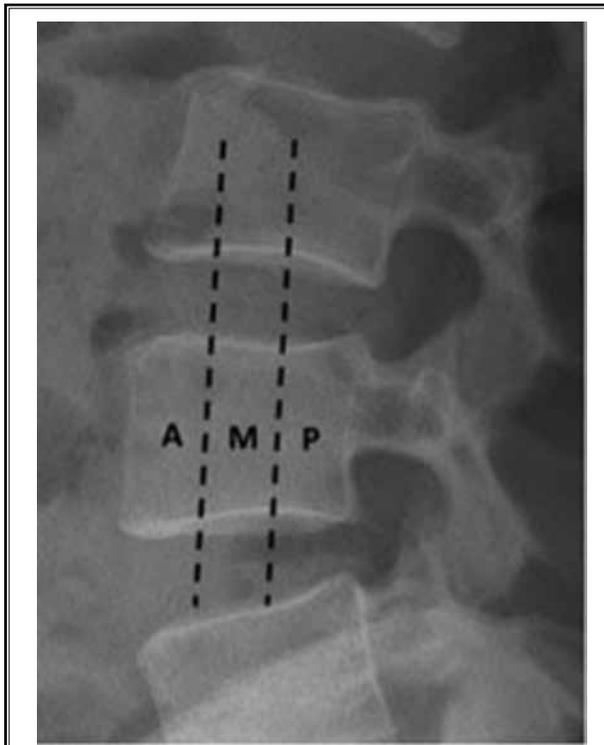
Lateral radiograph of the lumbar spine. Measurement technique for the determination of endplate extravasation location. The vertebral body was split into equal thirds defined as anterior (A), middle (M), and posterior (P).
